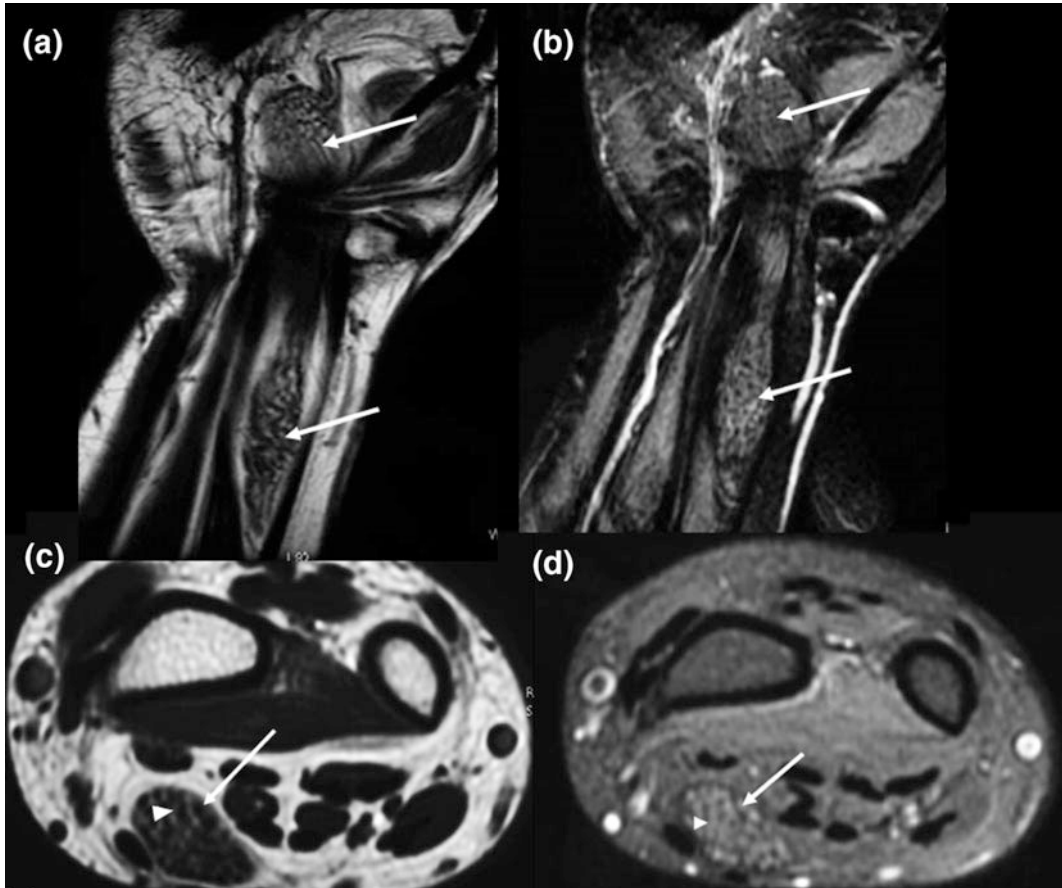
Fibrolipomatous hamartoma of the median nerve: MRI of the wrist, in a teenage with macrodactyly. Sequence coronal T2-weighted image (a), FAT SAT T2-weighted image (b), axial T1-weighted image (c) and, FAT SAT T1-weighted image (d), reveal adipose tissue surrounded the nerve fascicles of the median nerve, causing thickened nerve and enlargement of the carpal
